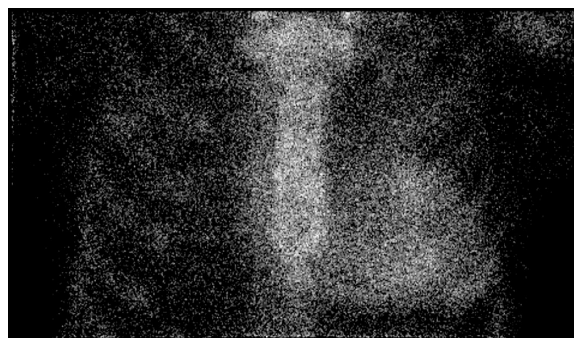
$^{99\text{m}}\text{Tc}$ -Pyrophosphate scintigraphy showed increased H/CL ratio (1.59, the normal ratio is < 1.3) and grade 3 accumulation throughout the left ventricle.
